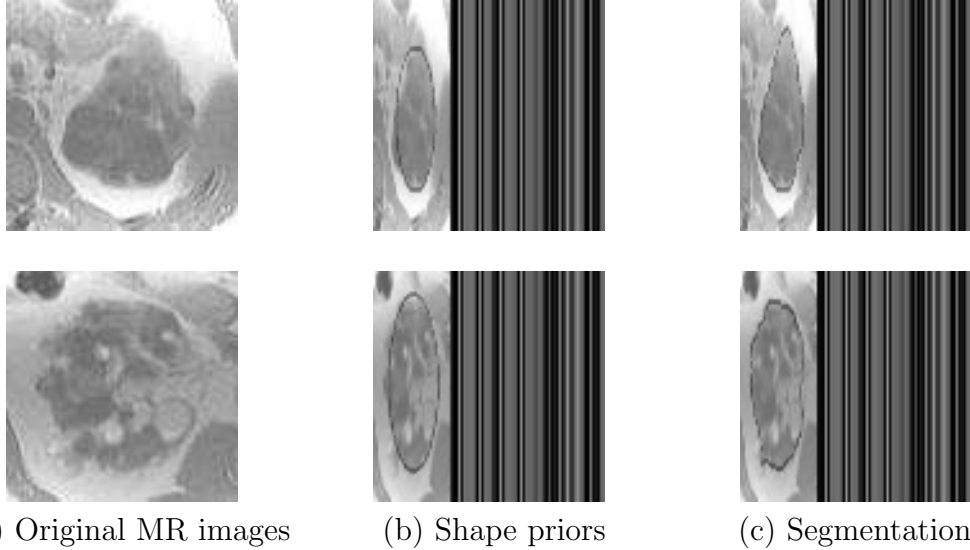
Two kidney segmentations obtained by our method are shown in each row. The left column shows the original MR images, the middle and right column shows the shape priors and segmentations obtained by our method. Although these images have weak contrast at boundaries and strong contrast within the kidney, our method was able to segmentation them accurately.
